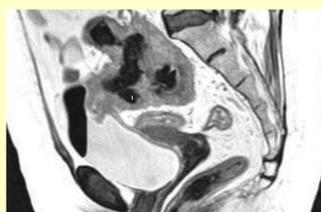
MRI scan shows the fistulous between bladder and bowel in a Crohn's disease patient.
